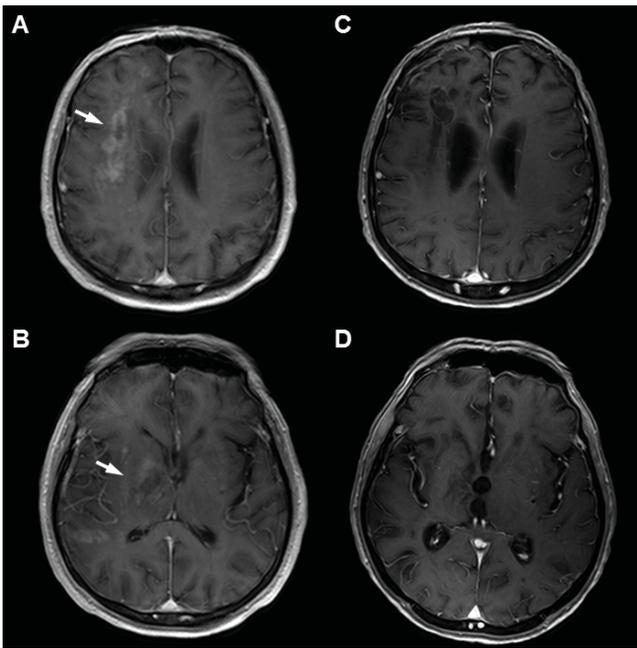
Axial contrast-enhanced brain MRI showing areas of enhancement (arrows in A and B) in the right basal ganglia, thalamus and subcortical frontal white matter lesions with resolution after mefloquine therapy (C and D).
